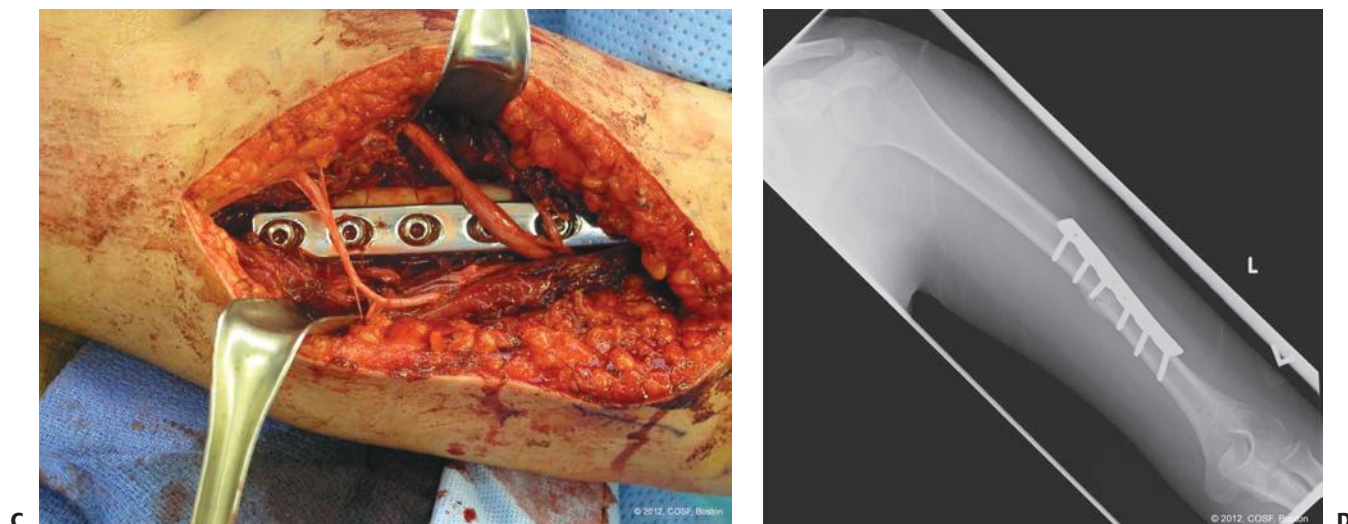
(continued) C: After irrigation, debridement, and plate fixation of the fracture, the nerve can be seen decompressed overlying the implant. D: Postoperative radiograph depicting bony healing and implant placement.
